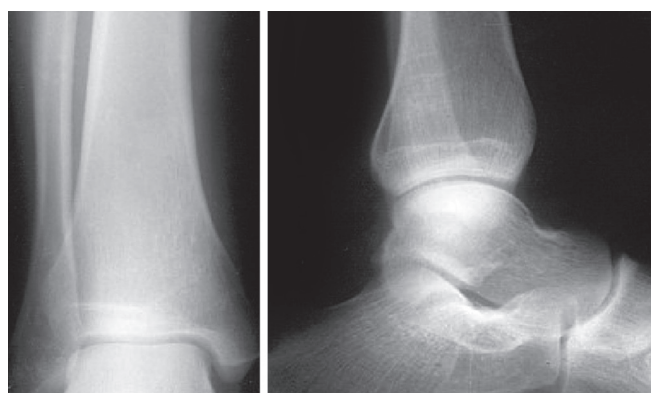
One year follow-up X-ray
